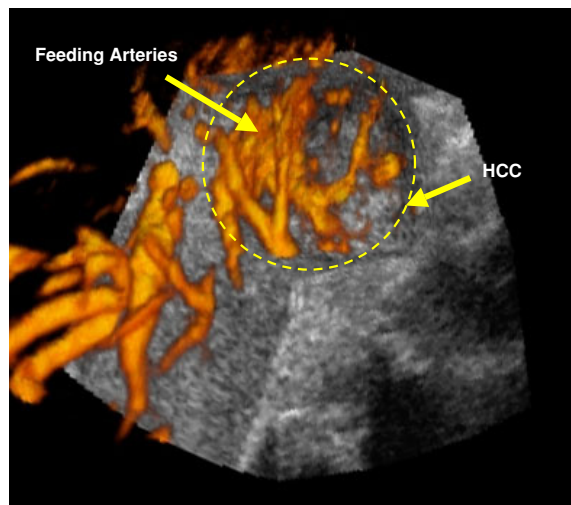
3D ultrasound image obtained by fusion of a B-mode image for hepatocellular carcinoma (HCC) and a Doppler image with contrast enhancement for feeding arteries (courtesy of National Institute of Radiological Science).
